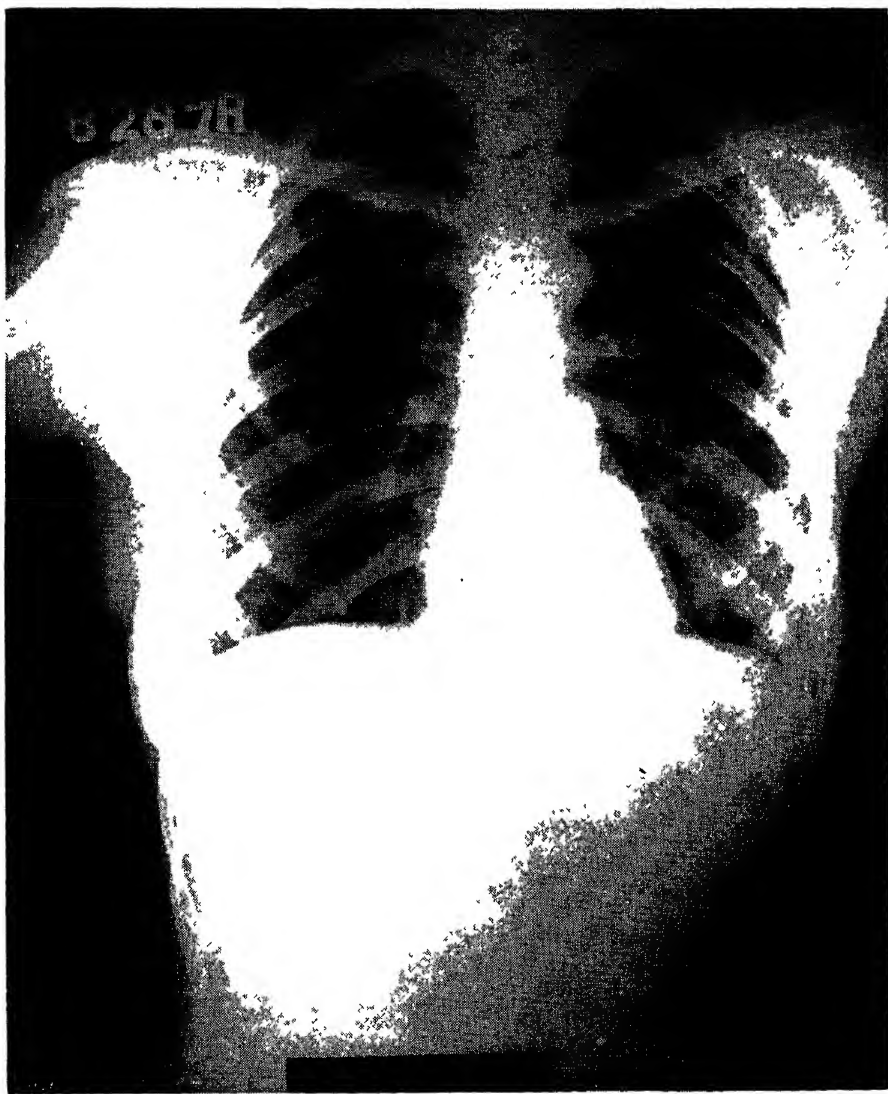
Roentgen ray made 5 days later showing rapid return to normal of the right lung after bronchoscopic removal of the obstructing growth (Baum Ann Int Med, Nov, 1938)
